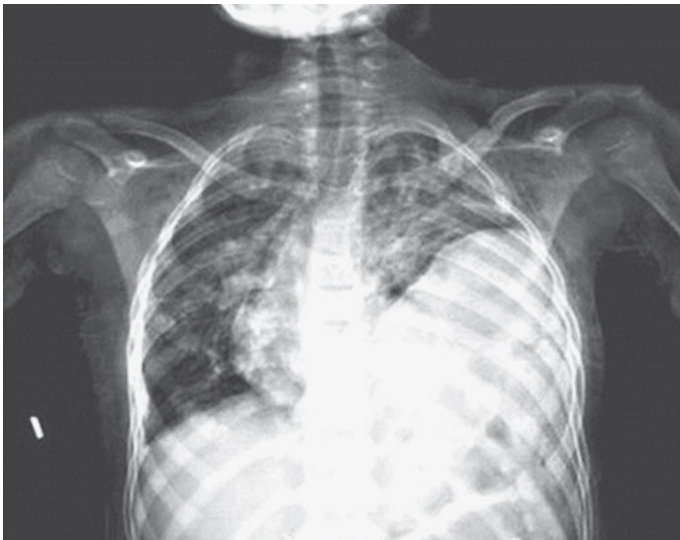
Example of a radiograph of a left-sided diaphragmatic rupture with mediastinal shift to the right.
